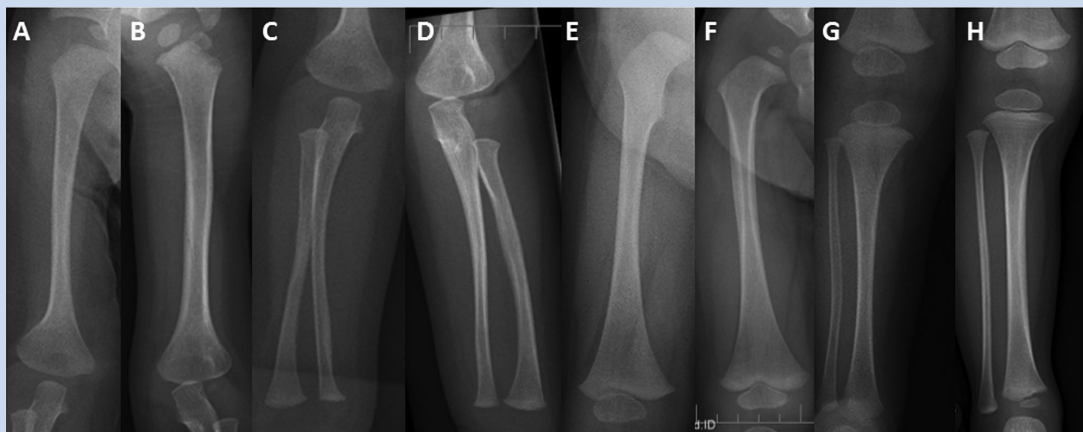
Radiographic features of long bones in patients with NBAS deficiency. Panels A, C, E, G: patient 1 at age 1 year (humerus, radius, and ulna, femur, tibia, and fibula, respectively). Panels B, D, F, H: patient 2 at age 2 years (humerus, radius, and ulna, femur, tibia, and fibula, respectively). Note mild osteopenia, slender bones with stenotic diaphyseal shafts (particularly in panels B, E, and G), flared metaphyses. Knee epiphyses are mildly flattened.
